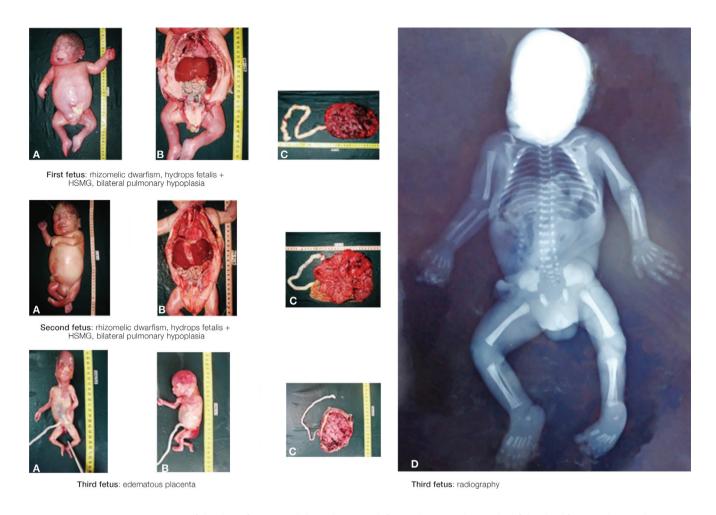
Macroscopic examination of the three fetuses and their placentas (left panel, A-C); radiography of the third fetus (right panel, D).
